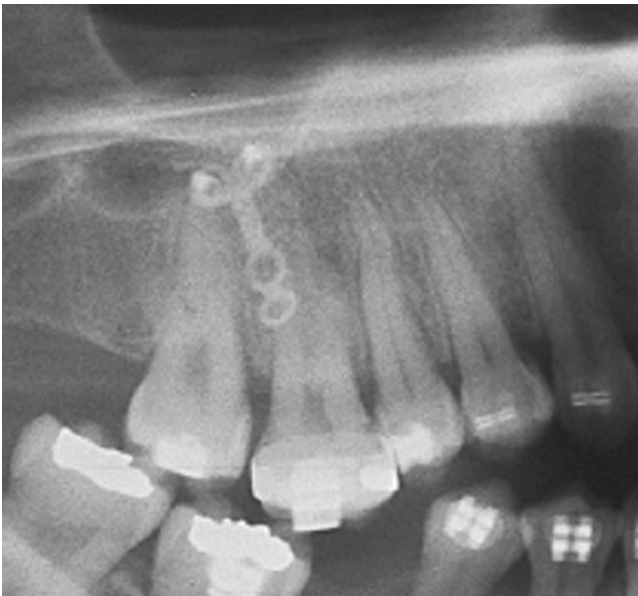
Pretreatment panoramic radiograph of patient 1.
